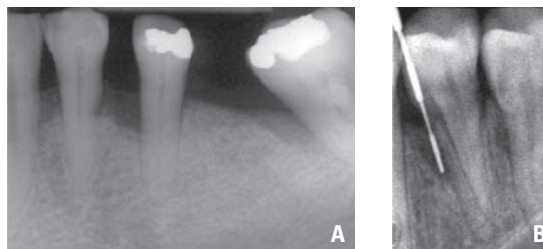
A. X-ray presentation of periodontal bone defect 34 and 36 with loss of tooth 35; B. Periodontal bone defect with periodontal testing probe.
